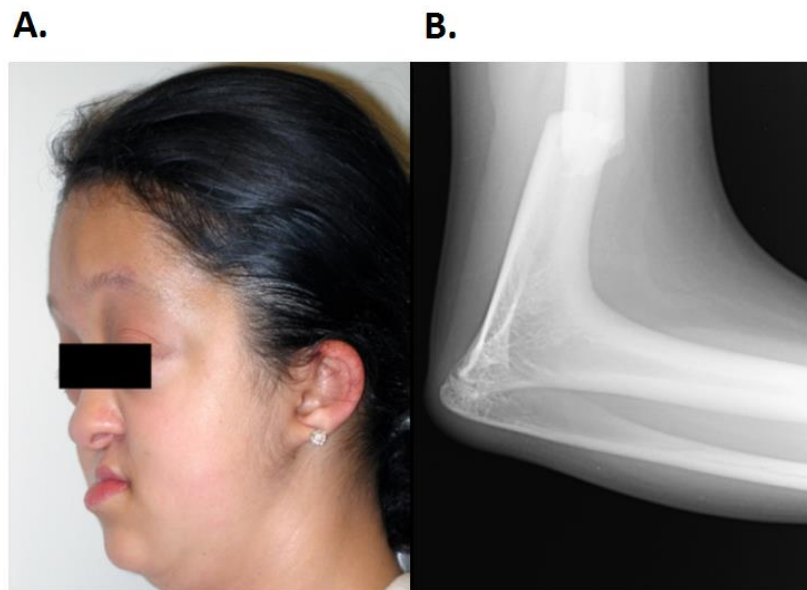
A female with Antley-Bixler syndrome and a radiograph showing radiohumeral synostosis. A. Photograph of 12-year-old female with Antley-Bixler syndrome. Typical low set ears with poorly formed antihelix and pear-shaped nose are presented. B. Right arm radiograph demonstrating radiohumeral synostosis and humeral fracture (McCall et al., 2007).
